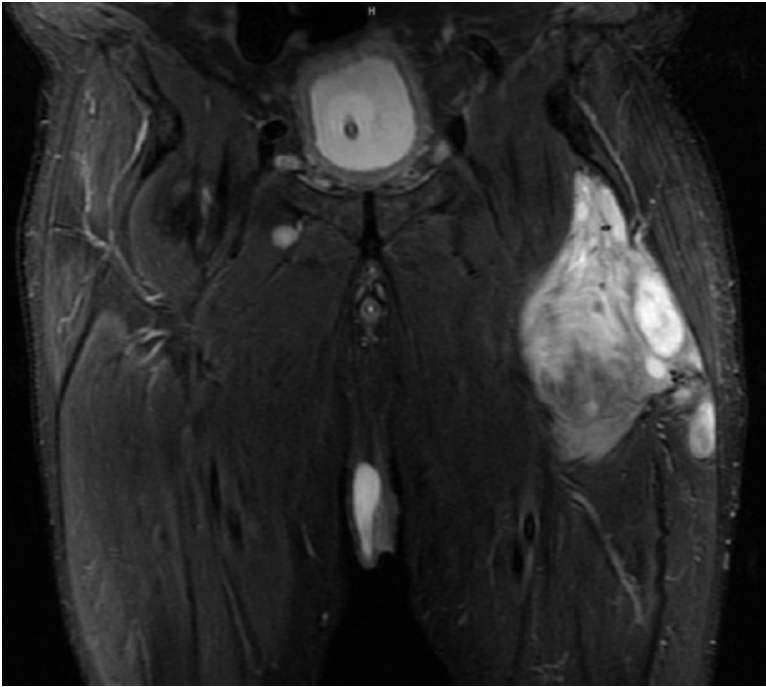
Mass on MRI, we can see great dimensions, deep position and vastus intermedius involvement (coronal STIR images).
